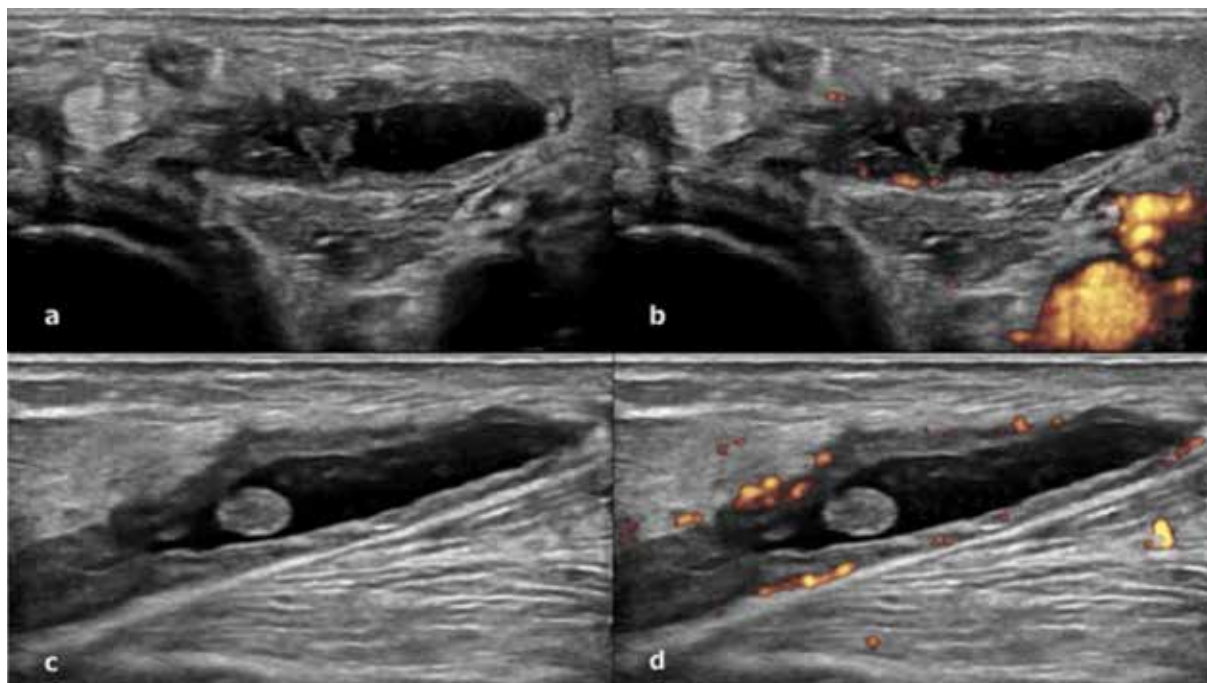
Baker's cyst in the posterior aspect of the knee. Power Doppler signal is positive in the proliferative tissue inside the cyst (b, d). a, b Transverse scans and c, d longitudinal scans.
